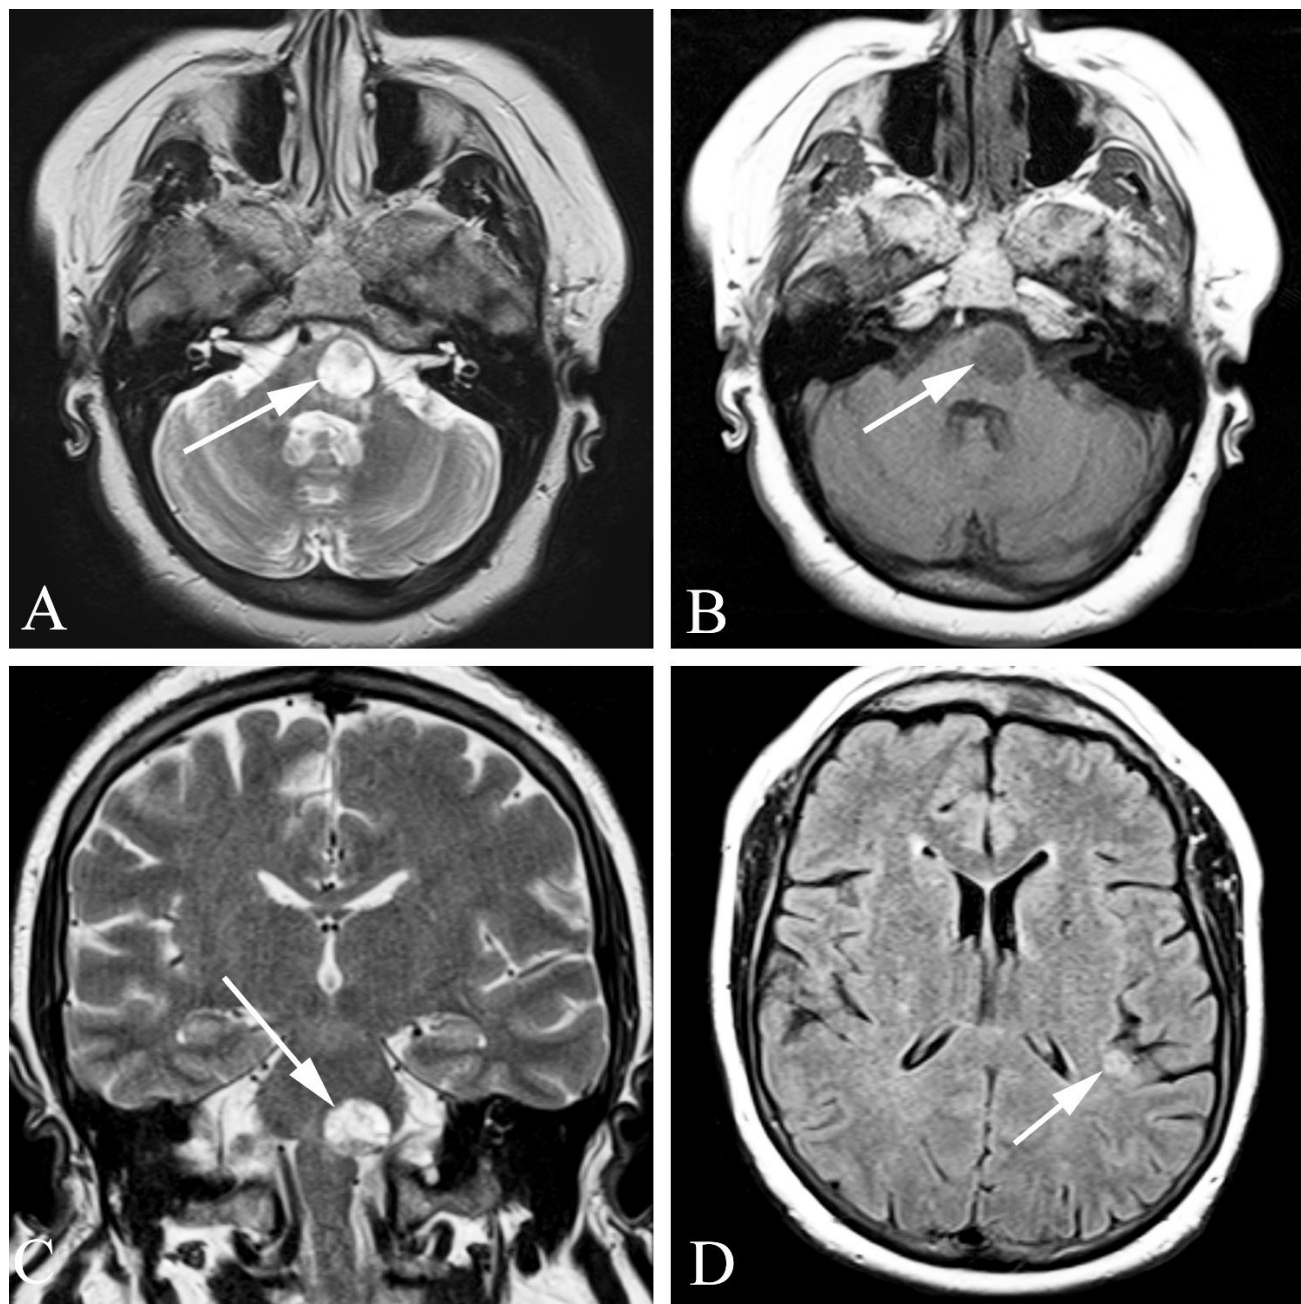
Metastatic disease in a 45 year old woman with tinnitus and headache who had a renal transplant. A. Axial T2 weighted MR image of the brain shows a mass with mixed (mostly increased) signal in the left brainstem (arrow). B. Axial T1 weighted image also shows the mass, with decreased signal. C. Coronal T2 weighted MR study also shows the brainstem mass. D. Axial FLAIR MR image demonstrates an additional lesion of the left cerebral hemisphere (arrow). Initially, the main consideration was for multiple brain abscesses in this immunocompromised renal transplant patient. Further study shows no extensive systemic findings of infection, however, and the patient was found to have a small cell carcinoma of the lung.
